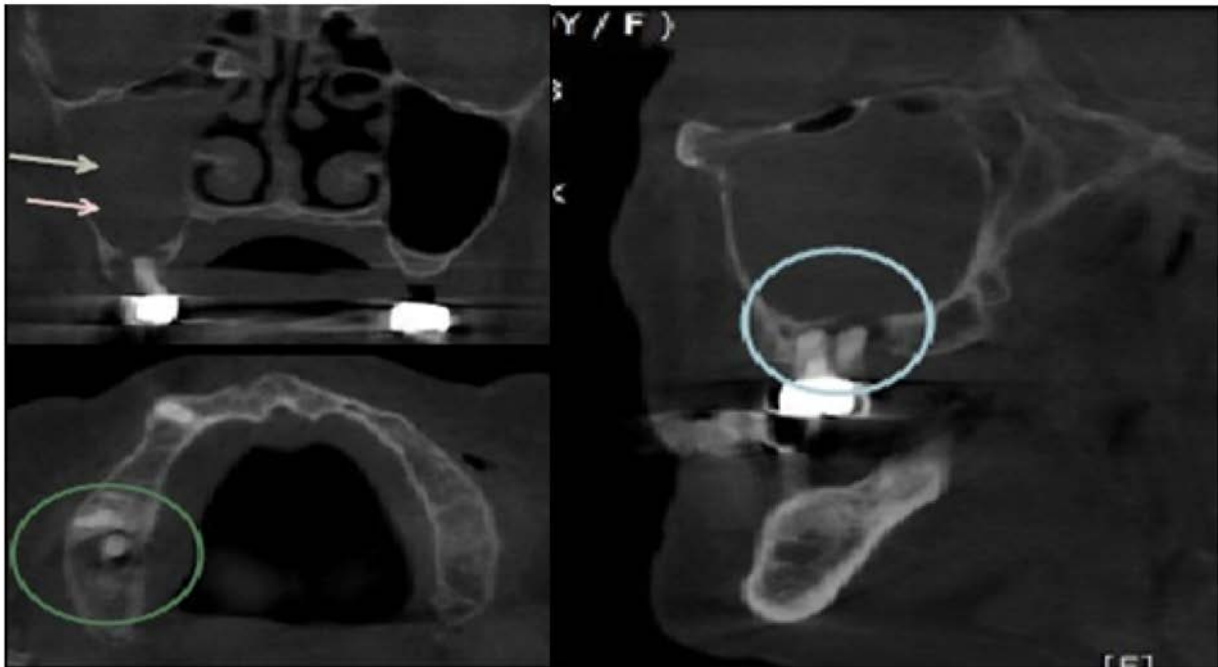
Pre-operative imaging of computed tomography scan showing sinus radiopacity indicative of inflamed sinus – Case I.
